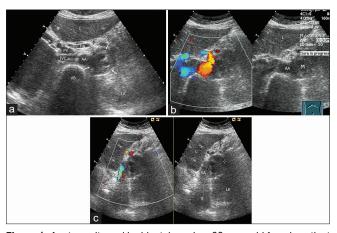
A retroperitoneal incidentaloma in a 63-year-old female patient with a urinary tract infection. (a) Transverse sonogram of the upper abdomen shows a mass lesion (arrows) with central cystic change in the left upper retroperitoneum, behind the pancreas (p). (b) Color Doppler (left panel, velocity setting of 53 cm) and corresponding gray-scale (right panel) transverse sonograms at the level of the celiac artery (CA) show the mass (m) in the left lateral to the abdominal aorta (AA). The mass lesion is thought to be in the left adrenal fossa. No detectable Doppler flow signal within the lesion. (c) Color Doppler (left panel) and corresponding gray-scale (right panel) longitudinal sonograms reveal that the mass (marked by + cursors) is posterior to the splenic vein (SV) and caudal (distal) to the splenic artery (SA) and between the liver (I), spleen (s), and left kidney (LK). HA, hepatic artery; IVC, inferior vena cava; PV, portal vein; VB, vertebral body
